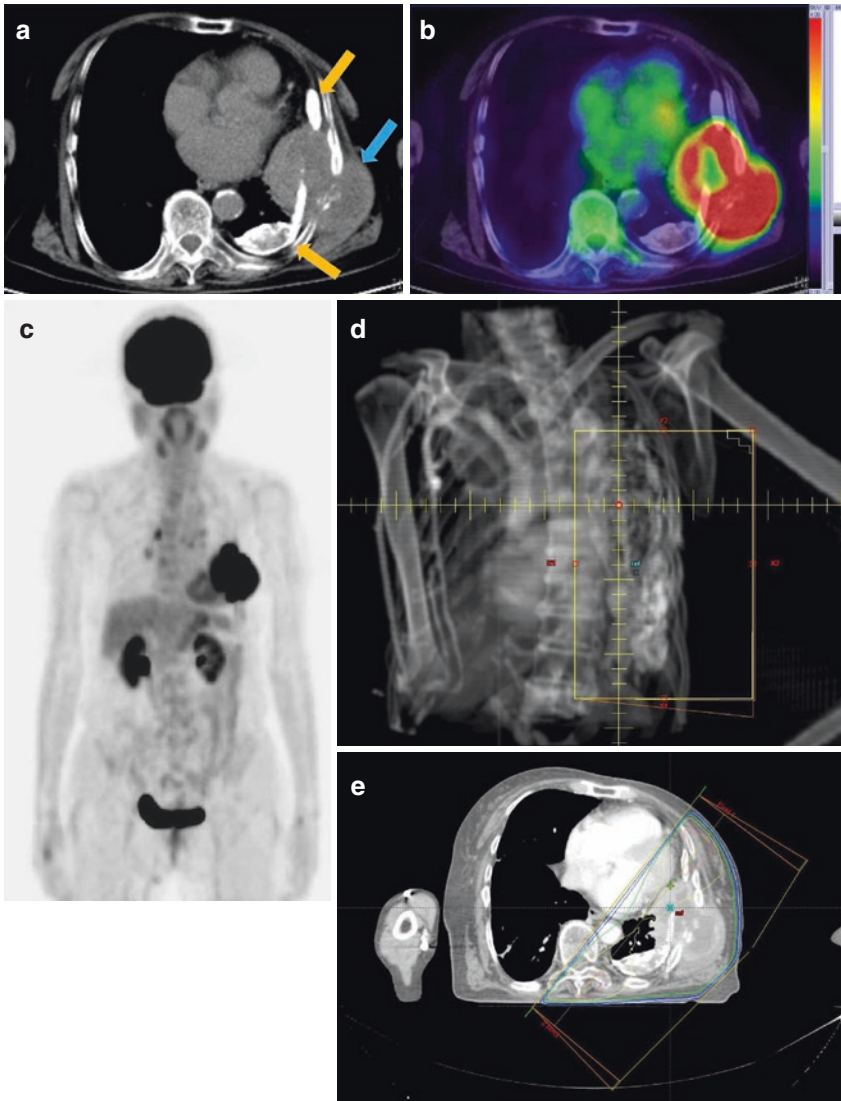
Eighty-seven-year-old female with stage I PAL treated only by radiation therapy including pyothorax cavity. The patient lived without relapse 5 years after the radiation therapy. (a) Axial CT image of PAL (*blue arrow*) neighboring pyothorax cavities with calcification (*yellow arrows*) before radiation therapy. PAL destructed ribs and invaded to the subcutaneous fat. (b) Axial FDG PET/CT image before radiation therapy. Marked FDG uptake was seen in PAL. (c) MIP frontal image of FDG PET/CT before radiation therapy. (d) Digitally reconstructed radiography (DRR) of the initial radiation portal including pyothorax cavities. (e) Medial margins of the fields were aligned to reduce dose to the heart. In these fields, 40 Gy in 20 fractions were applied. (f) DRR of the coned-down fields after 40 Gy. (g) The heart was mainly spared with the coned-down fields and an anterior part of the pyothorax cavity was not irradiated. With these fields 16 Gy in 8 fractions were applied. (h) Axial CT image after radiation therapy. PAL regressed almost completely. (i) FDG PET/CT after radiation therapy did not reveal increased uptakes in PAL. (j) MIP frontal image of FDG PET/CT after radiation therapy
